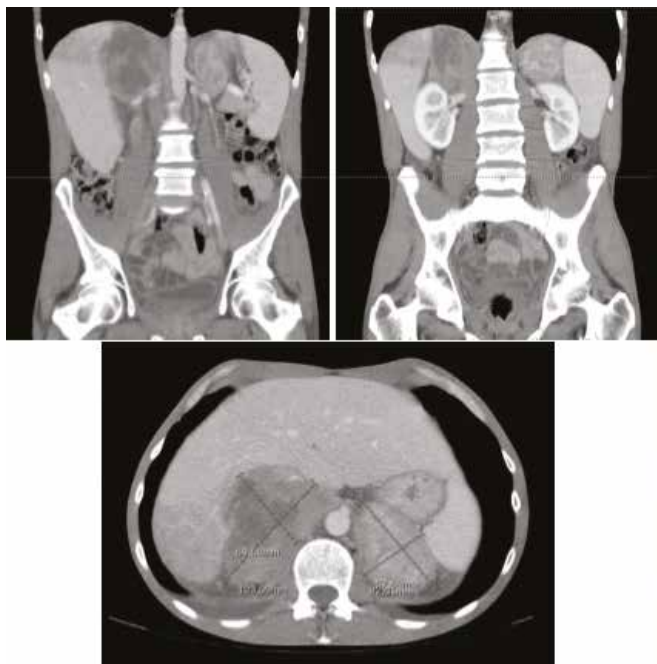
Abdominal CT-scan showing heterogeneous adrenal masses in both adrenal glands.
